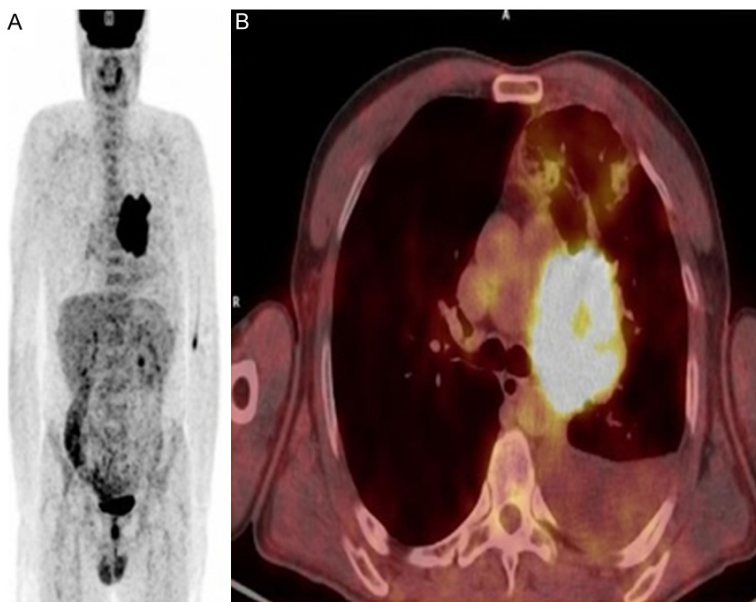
PET/CT images of 62 years old male with squamous cell lung cancer on left lung. SUVmax: 20 A. MIP images of PET C. Fusion PET/CT.
